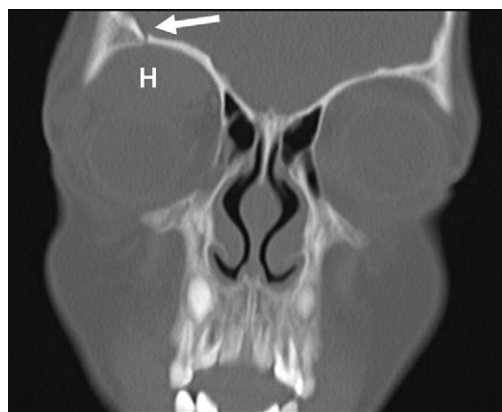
Coronal computed tomographic image.
